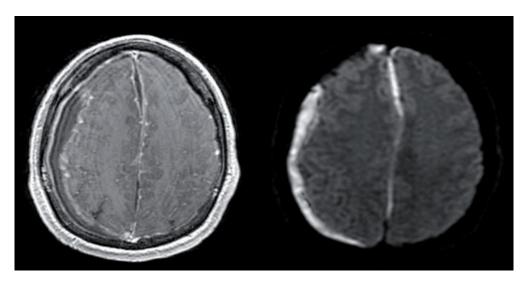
Contrast enhanced T1 MRI scan (left side) shows contrast enhancement on the arachnoid membrane and dura diffusely on the right hemisphere. Next to the falx cerebri similar alteration are seen and cavitation between falx and dura is noticeable. On the right sided image, we can see diffusion restriction in the hypointense areas seen on T1 sequences. These alterations show accumulation of pus in the subdural space.
